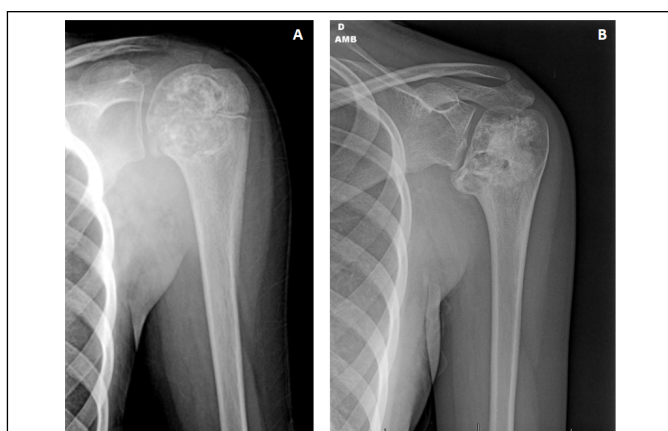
Shoulder X-ray of a patient with chondroblastoma
